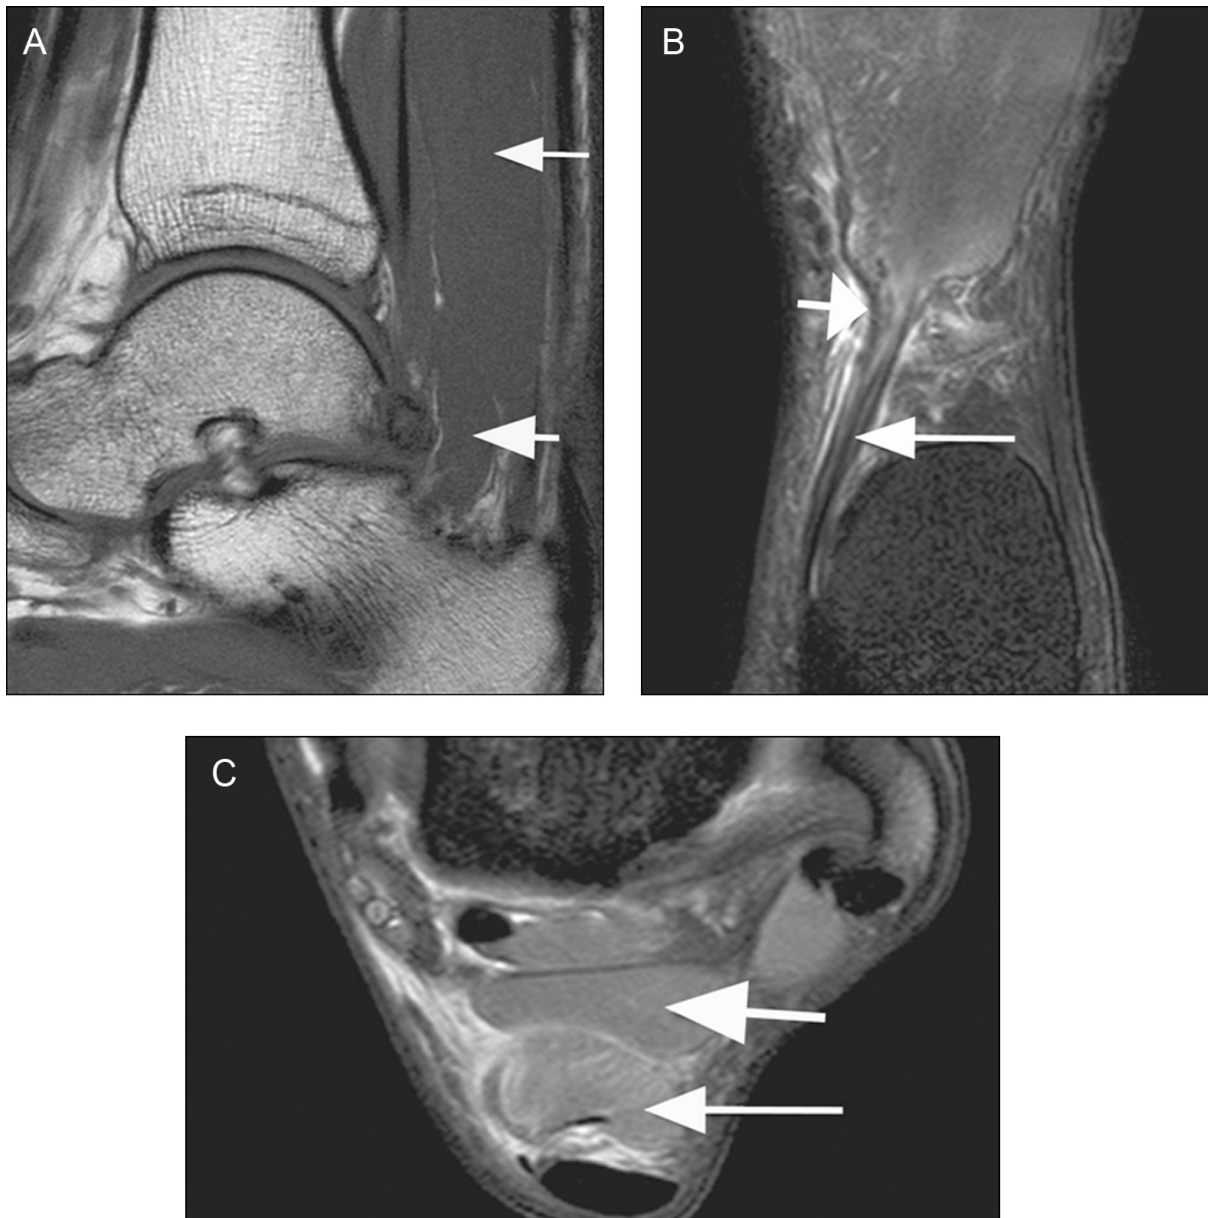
A 27-year-old male football player with accessory muscles causing posterior ankle pain. (A) Sagittal T1-weighted MRI shows co-existence of an accessory soleus muscle (long thin arrow) and an accessory flexor digitorum longus muscle and tendon (short arrow). (B) Coronal proton density-weighted fat-suppressed MRI shows tendon of the accessory soleus muscle (long arrow) and oedema at the myotendinous junction (short arrow). (C) Axial proton density-weighted fat-suppressed MRI depicts a normal accessory flexor digitorum muscle (short arrow) and a strain at the myotendinous junction of the accessory soleus (long arrow).
